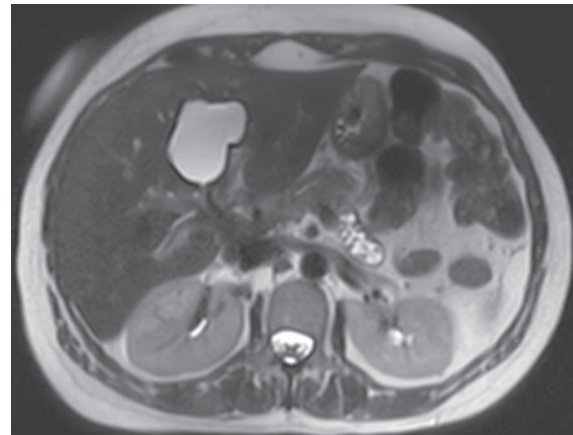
Axial MRI T2 phase showing unilocular cyst.
